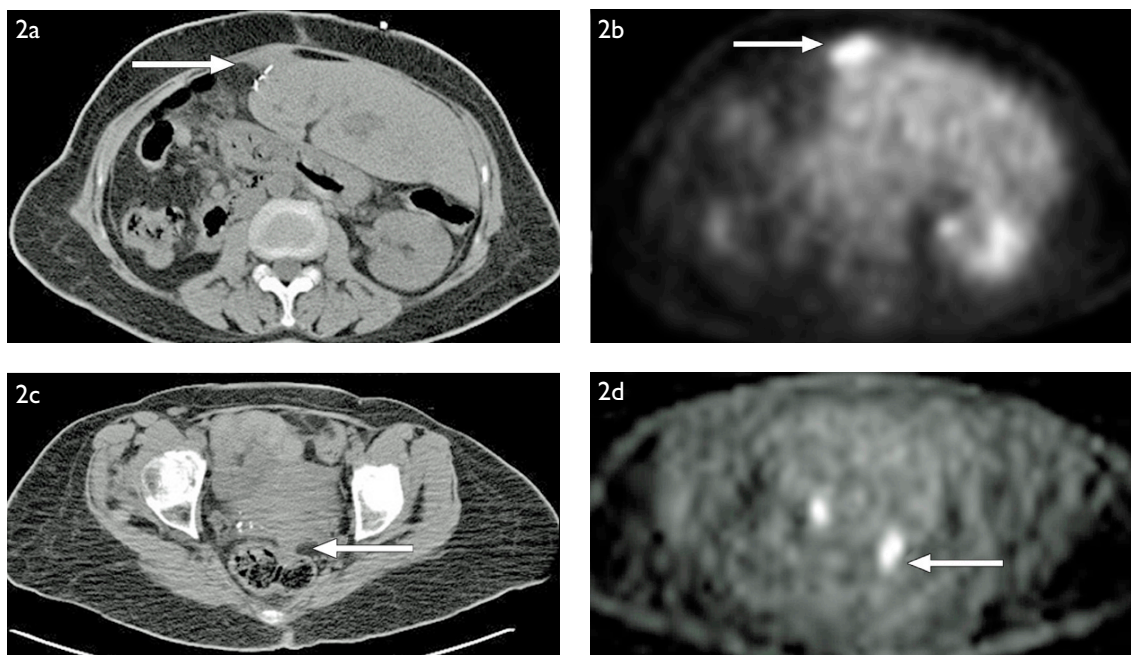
(a) Non-contrast-enhanced CT image shows soft tissue at the surgical resection margins (arrow), raising suspicion of local tumour recurrence. (b) F18-FDG PET-CT image shows that the soft tissue at the surgical margins (arrow) was markedly FDG-avid, indicating local tumour recurrence. (c) Non-contrast-enhanced CT image shows a soft tissue nodule in the pouch of Douglas (arrow), indicating peritoneal deposit. (d) F18-FDG PET-CT image shows that the soft tissue nodule was markedly metabolic-avid (arrow). All features suggested local tumour recurrence, with peritoneal metastatic deposits.
